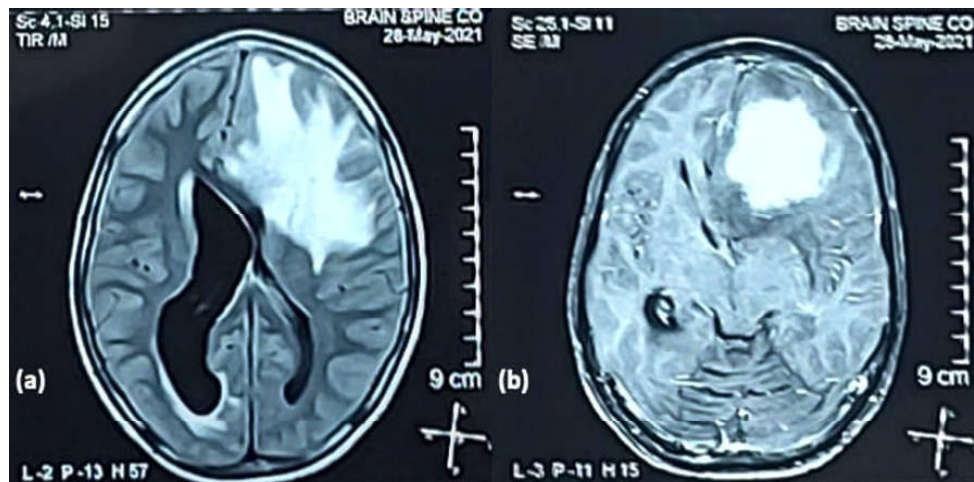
T1 weighted MRI showing hypointense solid soft mass lesion in Frontal Basifrontal lobe.
